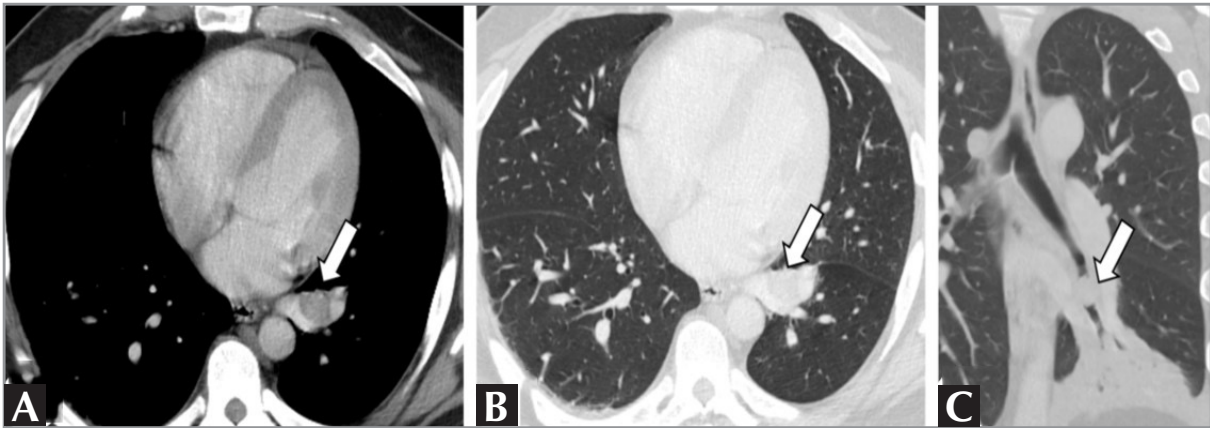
(A,B). Axial contrast-enhanced chest CT images (mediastinal and lung window, respectively) depict a well-defined endobronchial lesion arising from the left lower lobar bronchus. (C). Cropped coronal chest CT image shows a smooth, solid endobronchial nodule (arrows).
